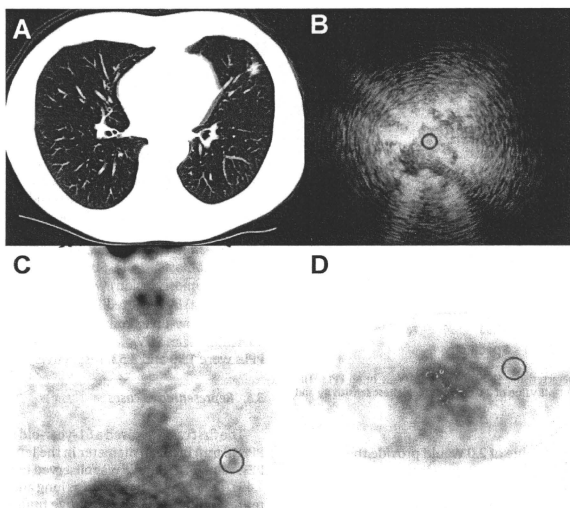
Images from a 61-year-old man with lung adenocarcinoma showing false-negative findings on FDG-PET. (A) On chest CT, a small PPL 10 mm in mean diameter is seen in segment 4 of the left lung. (B) EBUS revealing the PPL, which was diagnosed as adenocarcinoma by TBB using EBUS-GS. (C and D) On FDG-PET, transverse and coronal scans demonstrate slight FDG uptake in the left upper lobe (SUV_{max} , 1.45).
